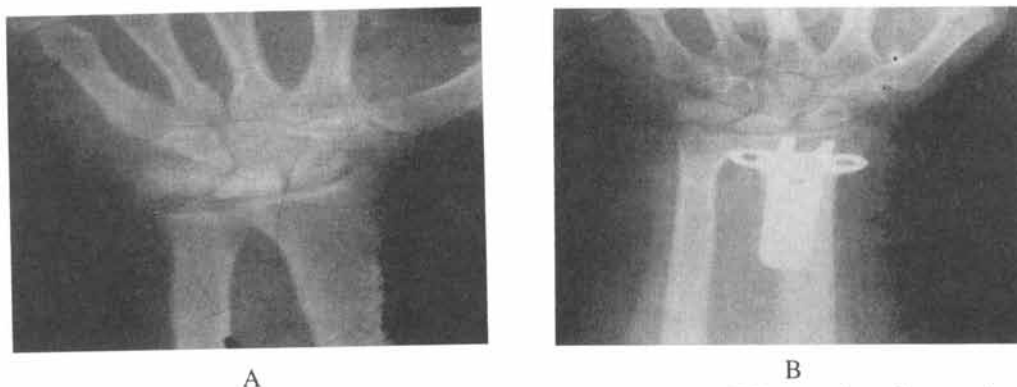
(A) Pre operative radiograph of a patient with stage (III), negative ulnar variant.
